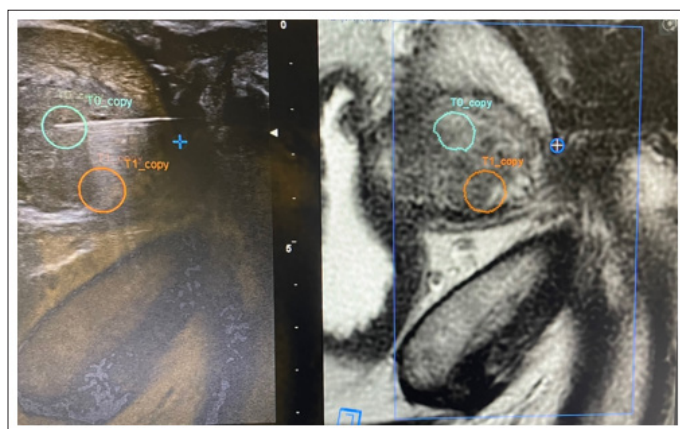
The Ultrasound Display shows the Ultrasound Image with Virtual Targets in Real Time on the Left and the mpMRI Image on the Right. The Hyperechoic Line in the Left Image is the Biopsy Needle During Sampling on a Target
